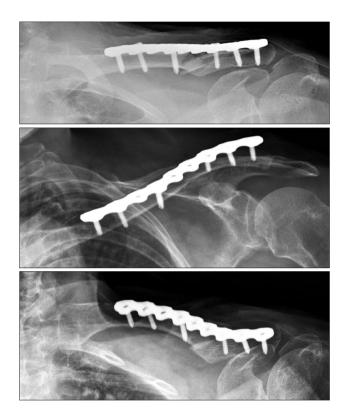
Postoperative radiographs show the restoration of clavicular length and realignment of comminuted segments.
